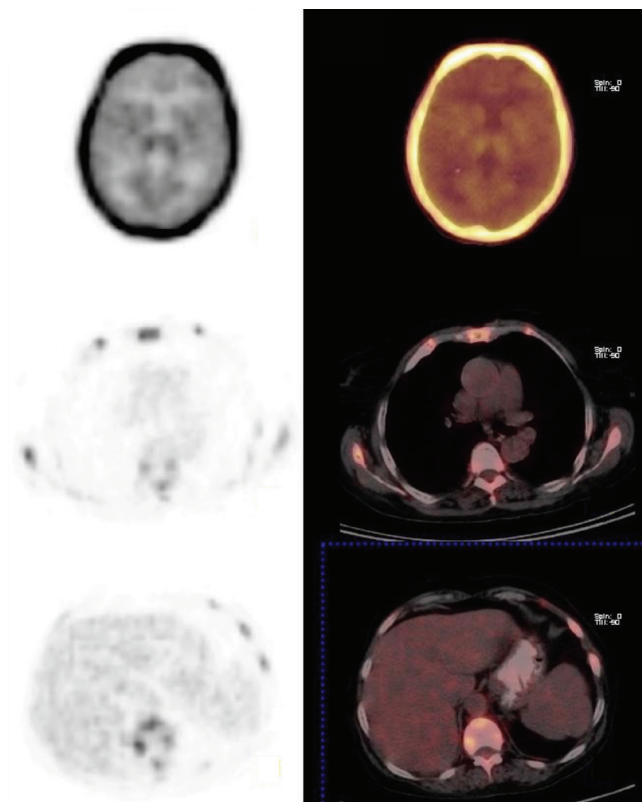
Interestingly the mediastinum, skeletal muscles of the limbs, bowel and especially the brain showed very low FDG uptake on ¹⁸F-FDG PET/CT. A parathyroid adenoma failed to be detected by FDG PET. A similar article described by Demir et al. (6) in 2007 reported FDG PET and bone scan results in a patient with primary hyperparathyroidism as showing diffusely increased tracer uptake by the skeleton, reflecting metabolic bone disease. However, to the best of our knowledge, superscan secondary to hyperparathyroidism caused by parathyroid carcinoma has not been reported previously and is described herein
